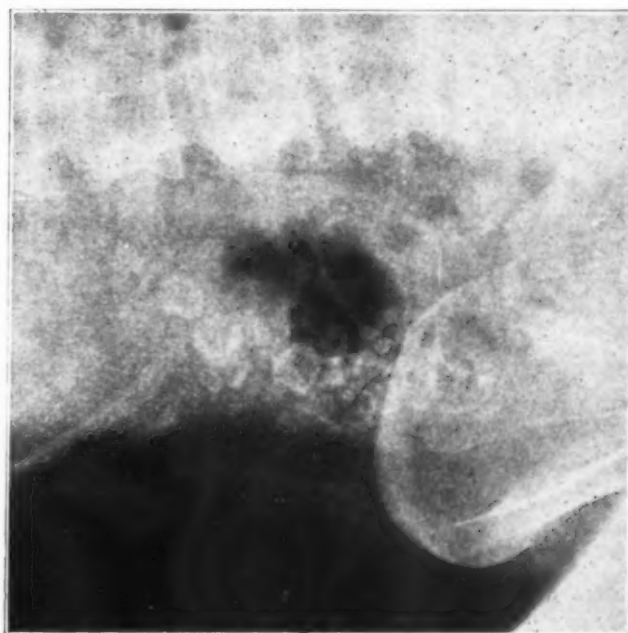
X-ray plate showing gall bladder filled with stones. (Compare with figure 3.)
